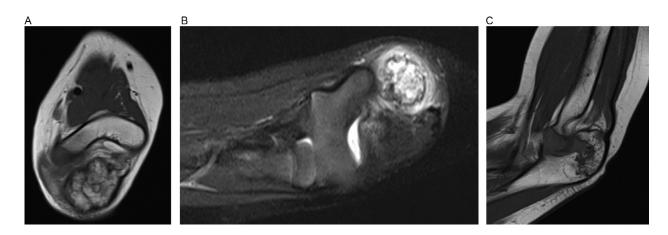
MRI without Gadolinium enhancement of the right elbow obtained at 2 years and 4 months of age. Axial (A), coronal (B), and sagittal (C) views showing an ossified mass with surrounding edema, extending from the proximal aspect of the ulna into the triceps muscle.
